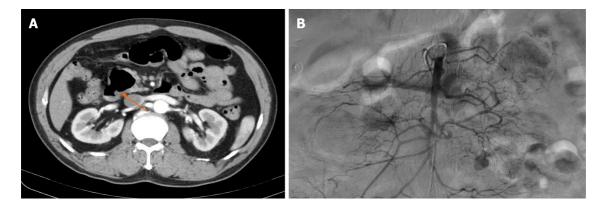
Preoperative image examinations. A: The abdominal computed tomography showed dilated small bowel loops with multiple jejunal diverticula (orange arrow); B: No visible sites of bleeding were shown according to the mesenteric angiography.
